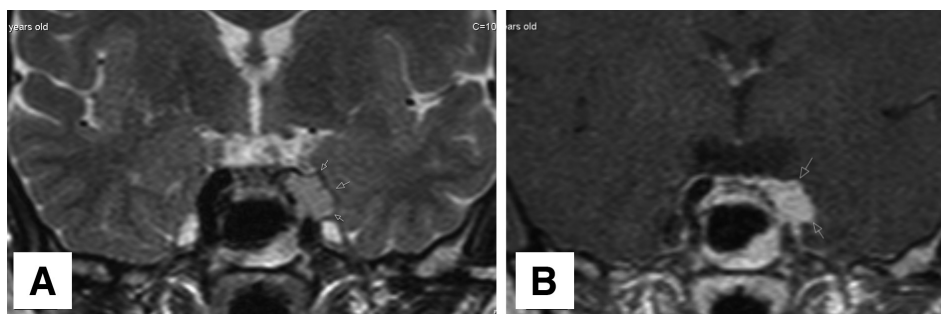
(A, B) Twenty months after the initial diagnosis, the patient developed sudden vision loss. The cranial magnetic resonance imaging T2 and post-contrast T1 weighted coronal images revealed a mildly T2 hyper-intense and homogeneously enhancing left parasellar mass compatible with metastasis. The patient received radiotherapy. Pituitary metastasis is very rare, accounting for only about 1% of pituitary surgeries (1). In the literature, although extraordinary metastasis sites of ACC were reported including the kidney (2) and vertebrae (3), there are only two cases reporting hypophysis metastasis (4,5)
